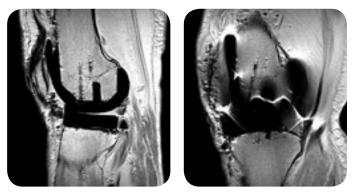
Sagittal MRI of a PEEK femoral component, Proton density (PD), turbo spin-echo (TSE) image (left). Sagittal MRI of a CoCr femoral component. Proton density (PD), turbo spin-echo (TSE) image (right).
